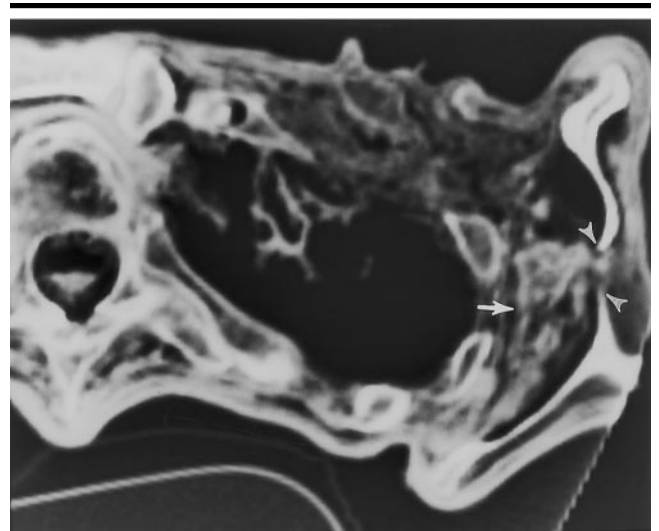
Transverse CT section (obtained on May 3, 1994) through the left shoulder (caudal to the prehistoric arrowhead) shows an inhomogeneous area of attenuation (dehydrated hematoma, arrow) between the lateral rib cage and the scapula. Note the discontinuity in the ossified body of the scapula and the wispy soft-tissue opacity (hematoma) that extends through the bone defect (arrowheads). We speculate that the arrowhead and a portion of the arrow shaft penetrated the scapula in this location and that blood from the deep hematoma followed the arrow track into the subcutaneous tissues.
